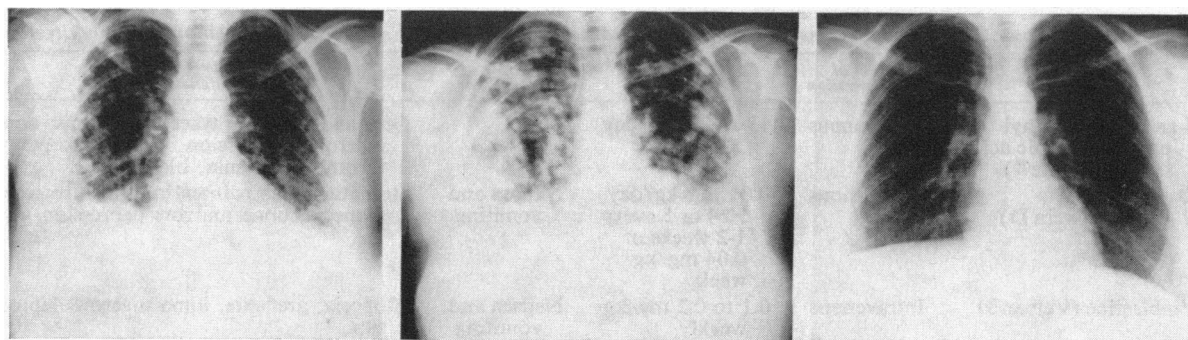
Chest roentgenograms before therapy (left); showing disease progression after Methotrexate (center), and regression of metastases after vincristine (right).
